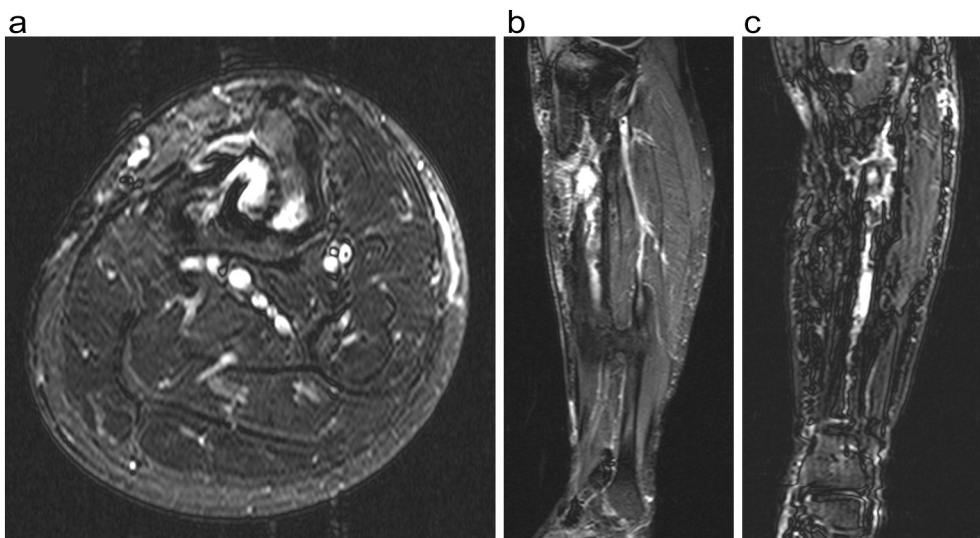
A, B, and C: MRI demonstrates this nidus formation with involucrum with sinus tract formation to the proximal tibia.
